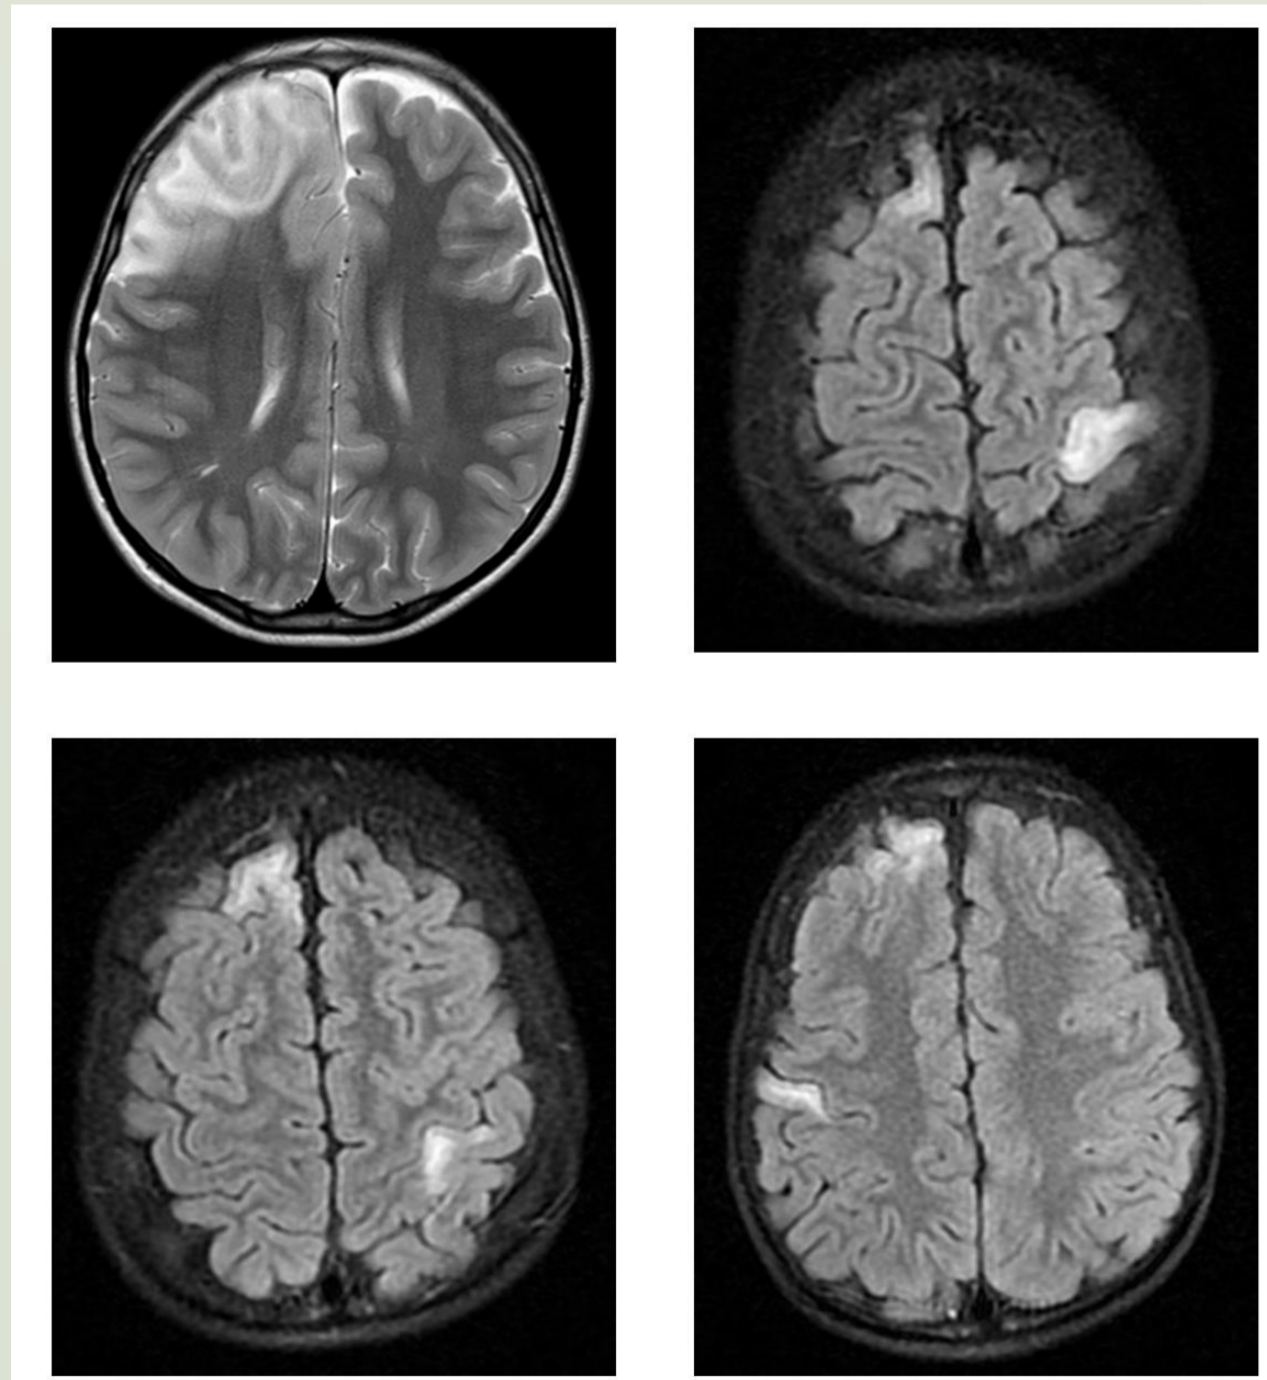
Brain MR images taken at three consecutive admissions. Hyperintense lesions and contrast enhancement in the right hemisphere frontal cortex, left hemisphere parietal cortex and right hemisphere parietal cortex on T2 enhanced images.
